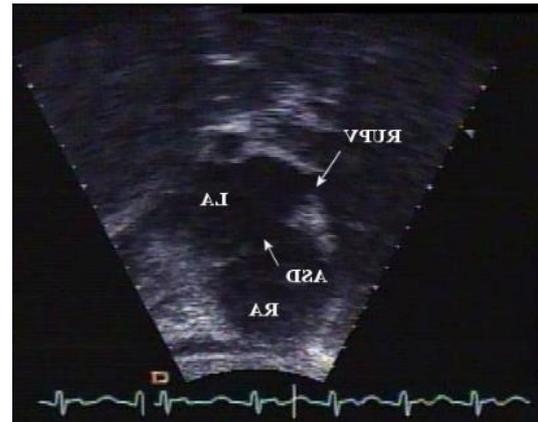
echocardiography of two months old infant with pks showing asd secundum type
